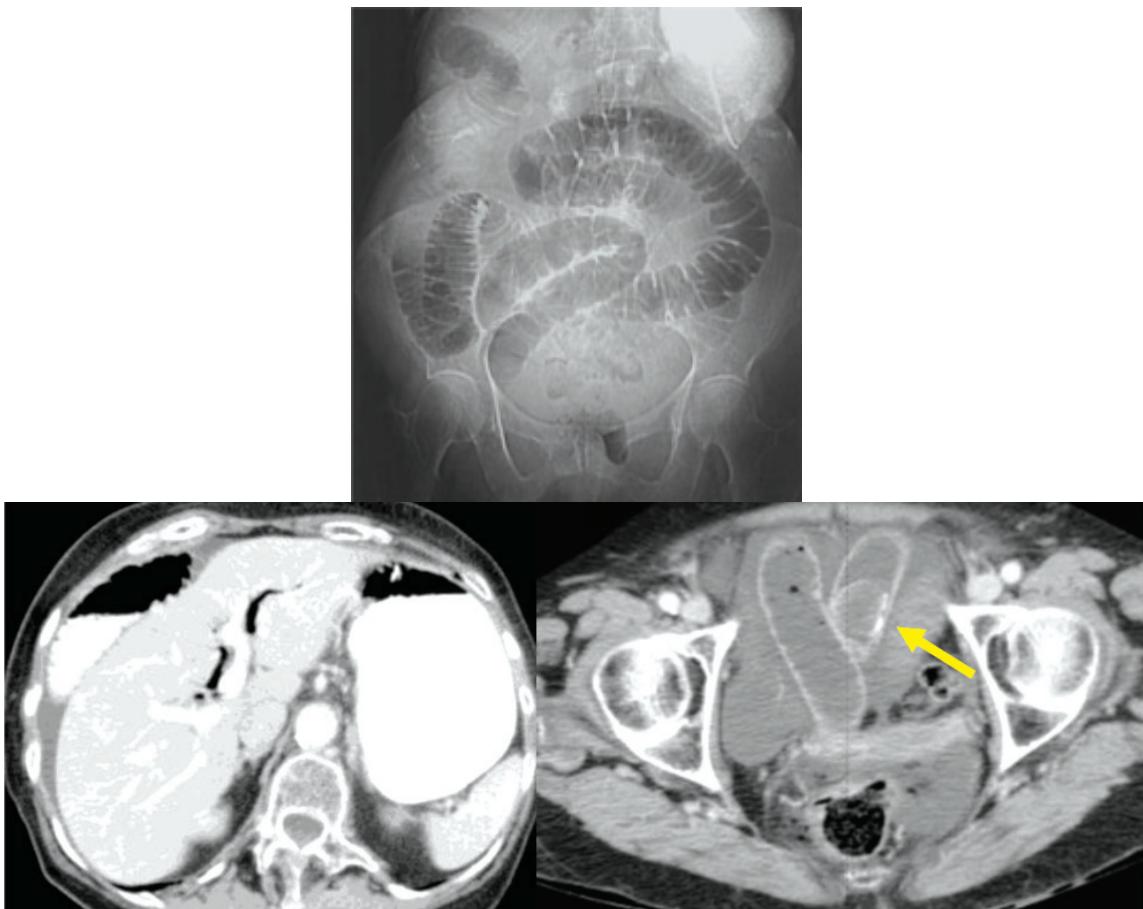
Gallstone ileus as a cause of obstruction; scout view of abdomen shows SBO. Axial views of CT abdomen show aerobilia, and ectopic gallstone (arrow) within small bowel loop. SBO, aerobilia, and ectopic gallbladder are called Rigler's triad of gallstone ileus.
